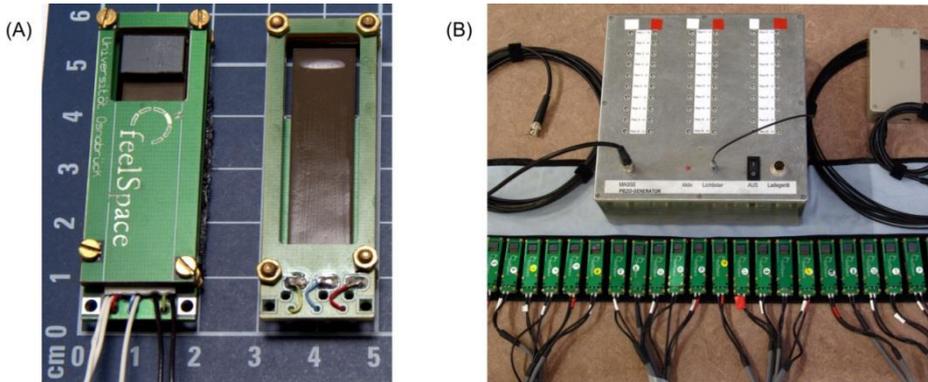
Details of the *feelSpace* belt. (A) Individual vibration elements feature casing, strain relief of power supply, piezo ceramic bending actuators, and a stamp. (B) The MRI compatible belt is connected by 60 coaxial cables to a filter box, which in turn is connected to the scanner room's Faraday shield. Figures taken from Keyser (Keyser, 2010) and under Creative Commons CC-BY-3 from Schumann (Schumann, 2012).
